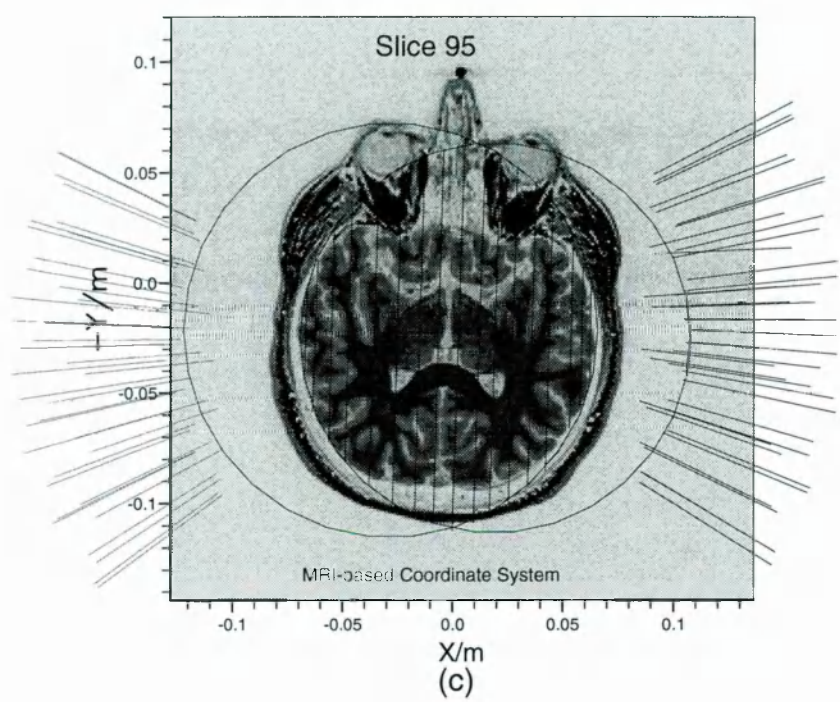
Axial view of the hemispherical source space for subject AI in two auditory evoked experiments obtained from (a) the KRENIKON 37-channel system; (b) and (c) the BTi twin MAGNES probe (2×37 channels). For the ease of comparison between the results from the two experiments for the same subject AI, the experiment set-up in the BTi head-based coordinate system as shown in (b) is also transformed to the MRI-based coordinate system as shown in (c).
